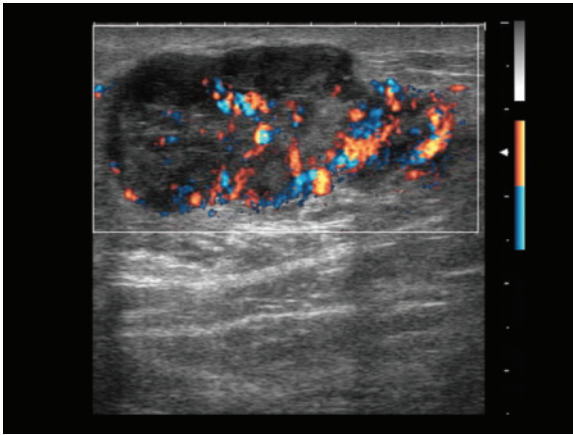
b Neurinoma of the leg. A lobulated mass with relatively homogeneous hypoechoic appearance and moderately vascular at directional PD can be identified in the proximal third of the leg (a). 3D CT reconstruction shows the displacement of the vascular structures adjacent to the mass (b)
